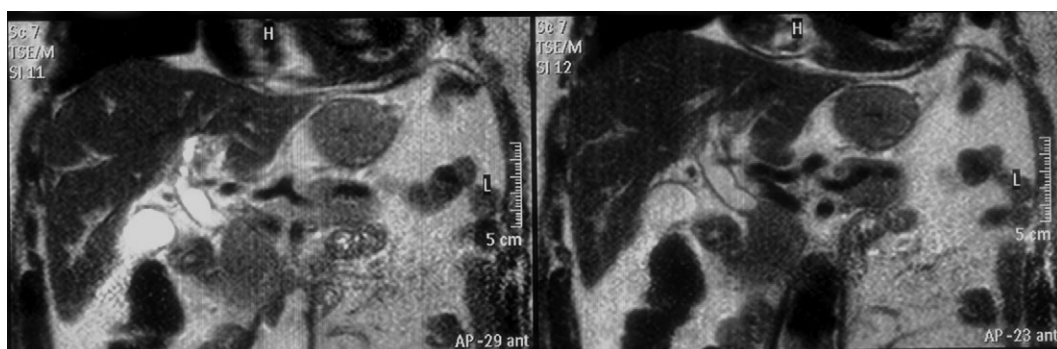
MRI showing dilatation of extra-pancreatic common bile duct
